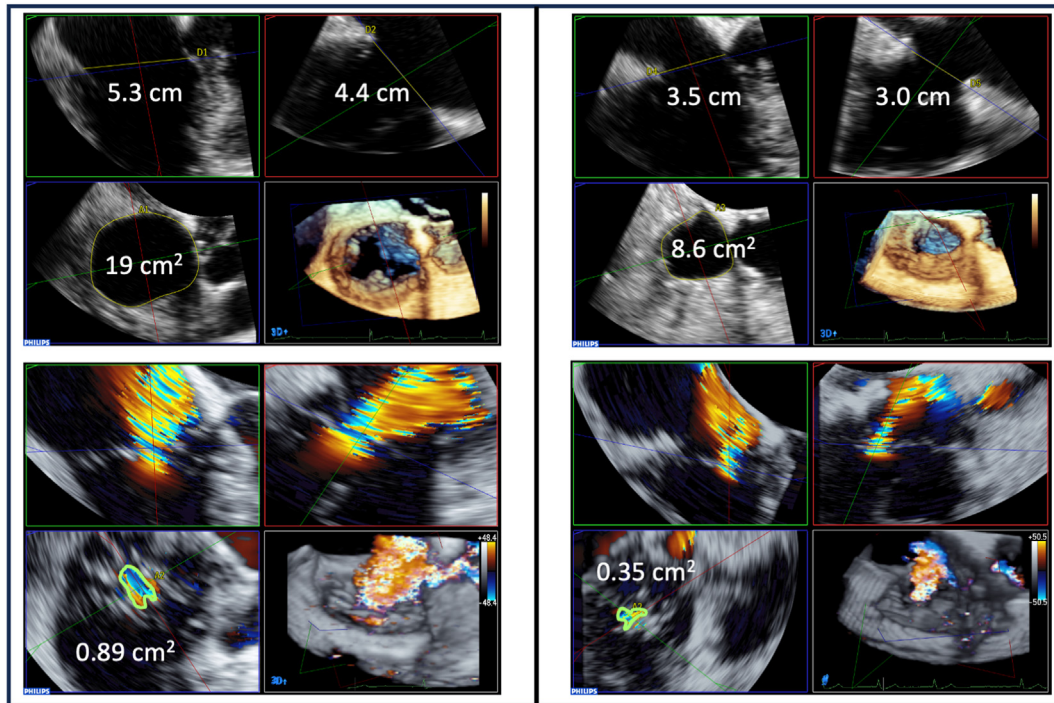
Three-dimensional echocardiography for TR severity quantification after TV annuloplasty. Annular size and VCA before (*left*) and after (*right*) TV annuloplasty are useful to quantify immediate annulare contraction (from 19 to 8.6 cm²) and acute TR reduction (from 0.89 to 0.35 cm²).
